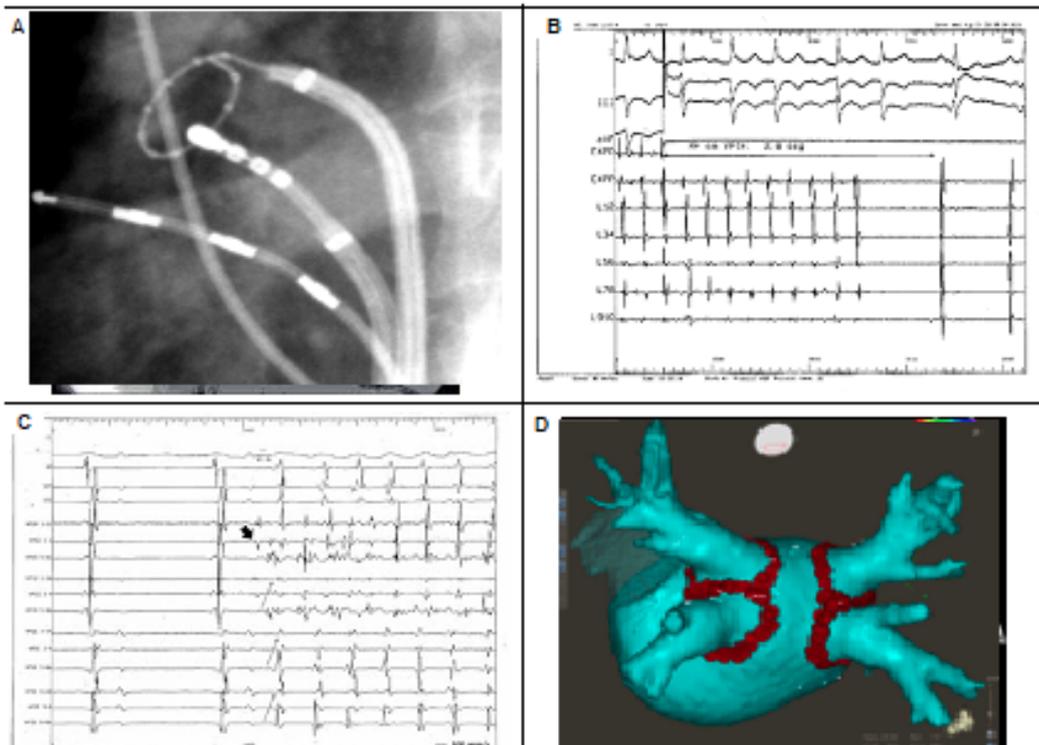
Images of pulmonary vein ablation for treatment of atrial fibrillation (AF). (A) Posteroanterior radiograph showing the insertion of microcatheters into pulmonary veins to detect the culprit vein. (B) Induction of AF. (C) Resolution of tachycardia and AF control after application of radiofrequency in the left superior pulmonary vein (LPSV) in another patient. (D) Electroanatomic voltage map of the left atrium in anteroposterior view, projected on a 3D model, showing the area of antral ablation and isolation of the pulmonary veins (red dots).
